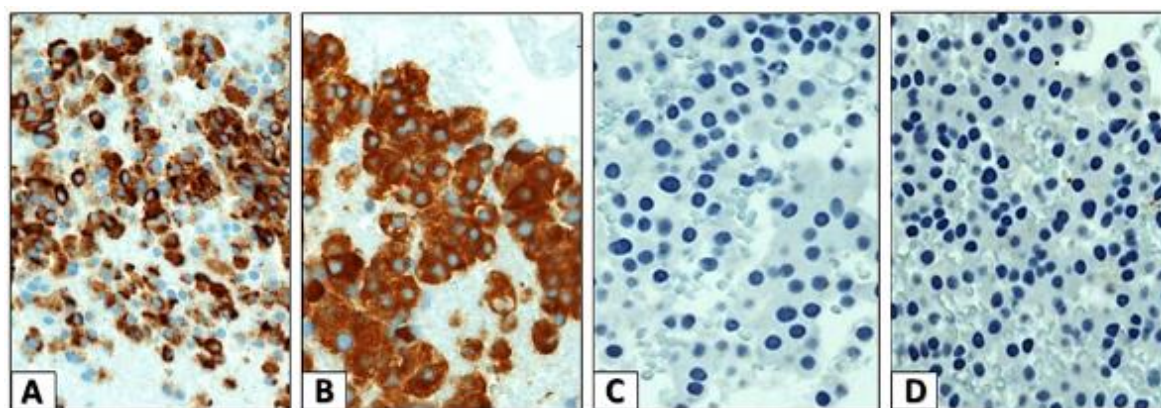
Cytomorphologic features of well-differentiated grade 1 Pancreatic Neuroendocrine Tumor (External Ultrasound-Fine Needle Aspiration, US-FNA)
